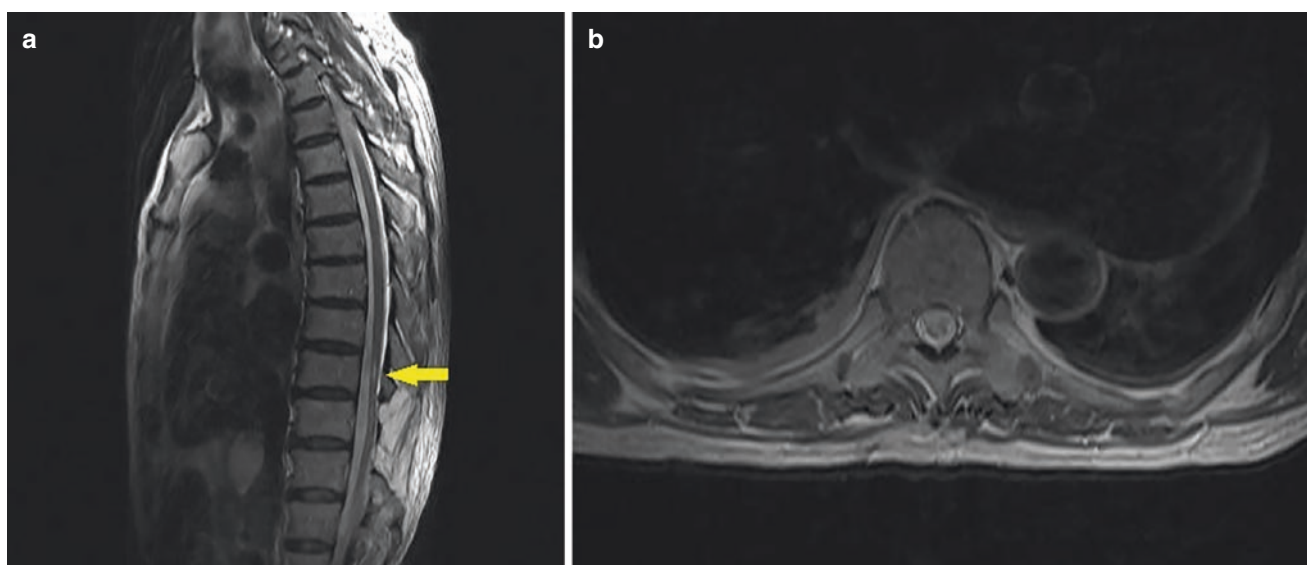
Preoperative MRI findings of thoracic vertebrae in patients with pain of lower extremities after intraspinal tumor surgery. (a) sagittal view (b) axial view
